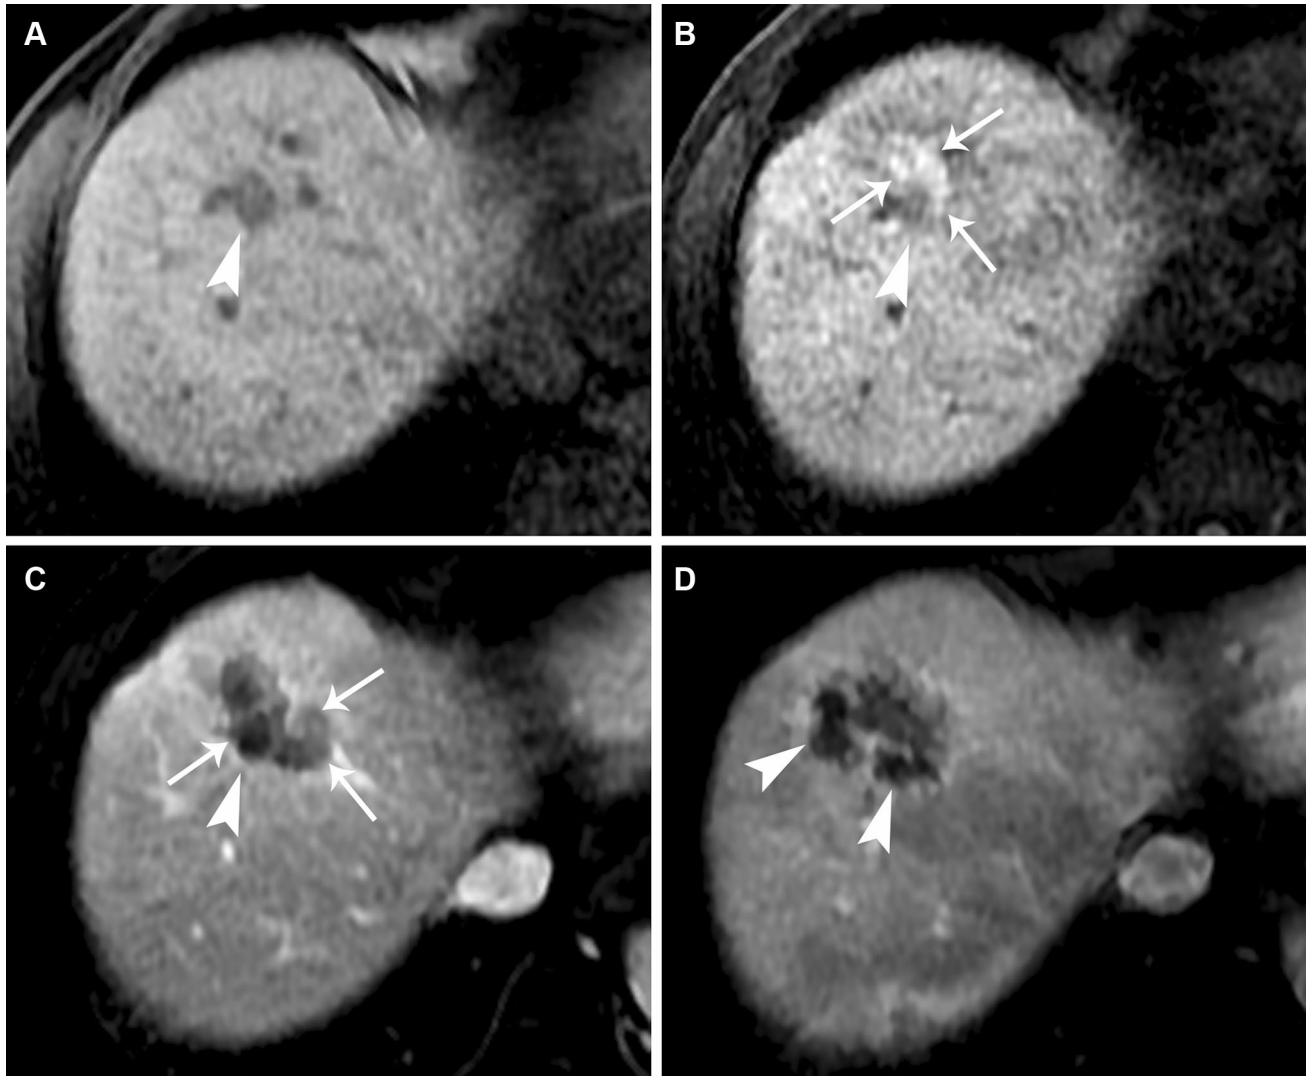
Residual tumor detected by non-enhanced T1-weighted imaging. A A metastatic lesion from colon cancer was detected in segment eight of the liver before ablation. B On the non-enhanced T1-weighted image, obtained 2 days after MWA, the hyperintense central zone (*arrows*) does not cover the lesion (*arrowhead*) completely [zone (-)], whereas
